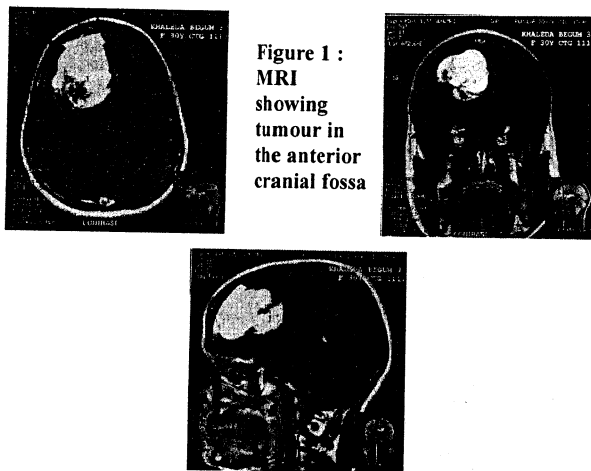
MRI showing tumour in the anterior cranial fossa
